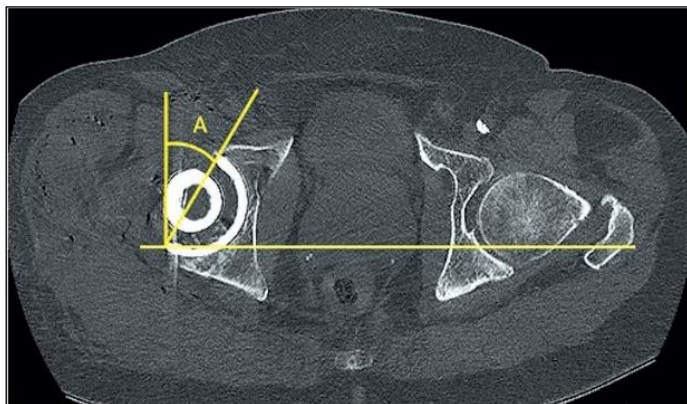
Anatomical cup anteversion using CT imaging
